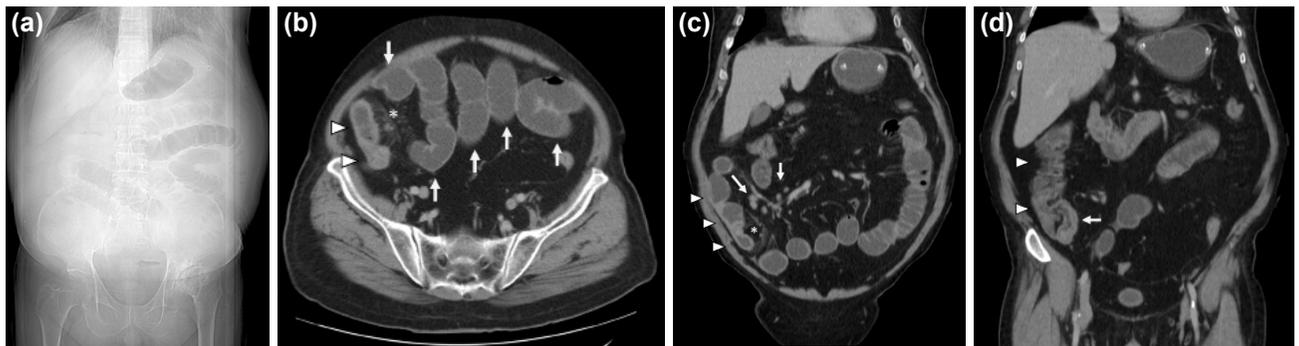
Abdomen CT scout image of patient in supine position (a) demonstrates distended stomach and small intestine segments with air, and diameter of the small intestine segments increased as well, compatible with intestinal obstruction. Axial contrast enhanced abdominal CT (b) demonstrates dilated small intestine segments (arrows), confirms scout image findings. Diffuse bowel wall thickening and contrast enhancement in the thickened bowel wall (arrowheads) with increased density adjacent mesentery (*) are seen in right lower quadrant, just before the terminal ileum (not shown in image). In coronal reformatted image (c), bowel wall thickening, long segmental involvement (arrowheads), and enlarged lymph nodes (arrows) in adjacent mesentery with increased density (*) are seen at right lower quadrant. In addition, involvement of terminal ileum (arrow) and lack of cecal and ascending colon involvement (arrowheads) are also seen in this coronal reformatted image (d).
